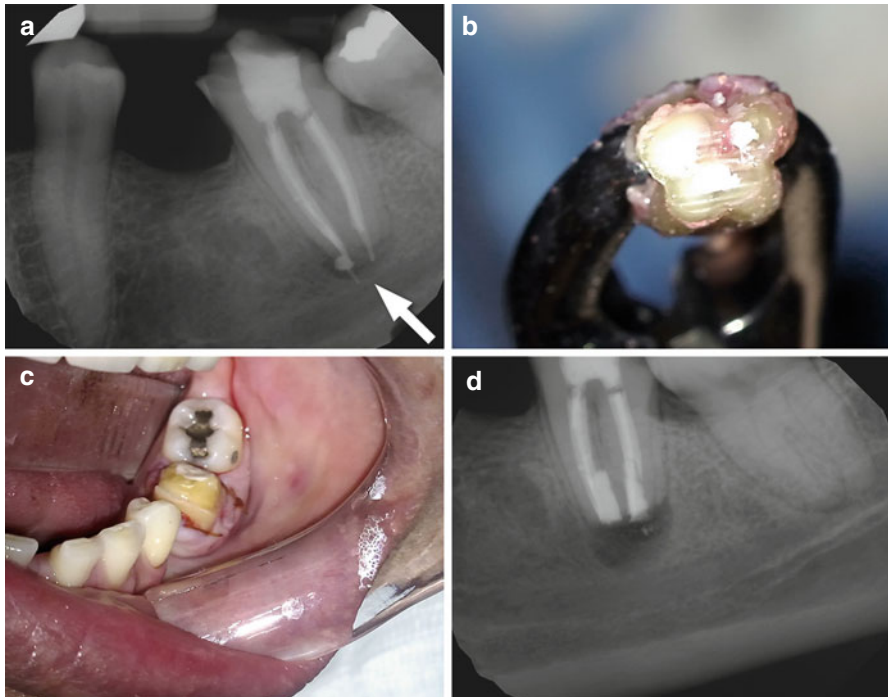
(a) After crown preparation and root canal treatment with significant overextension of root canal filling, this patient complained about persistent pain. (b) During intentional replantation, the tooth was gently lifted out of the socket and retrograde prepared. Care was taken to keep the periodontal ligament moist and the retrograde cavities were filled with Root Repair Material (Brasseler). (c, d) Clinical and radiographic condition immediately after replantation. The postoperative course for this patient was uneventful
